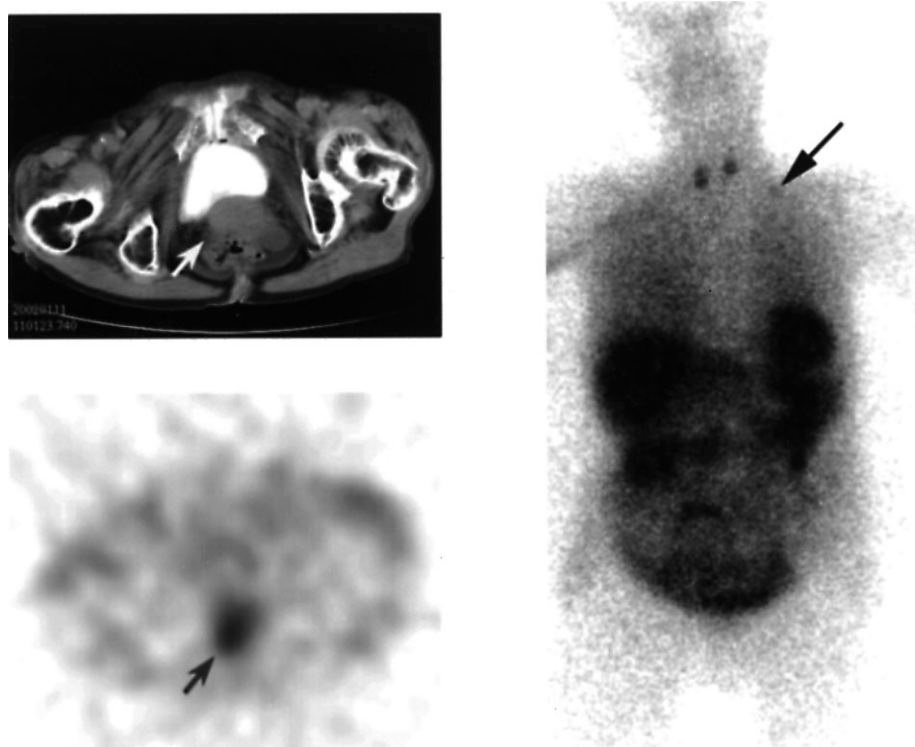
A case of cervical carcinoma defined by CT scan and high uptake from Tl-201 pelvic SPECT presenting with a left supraclavicular metastatic lymph node (arrows).
